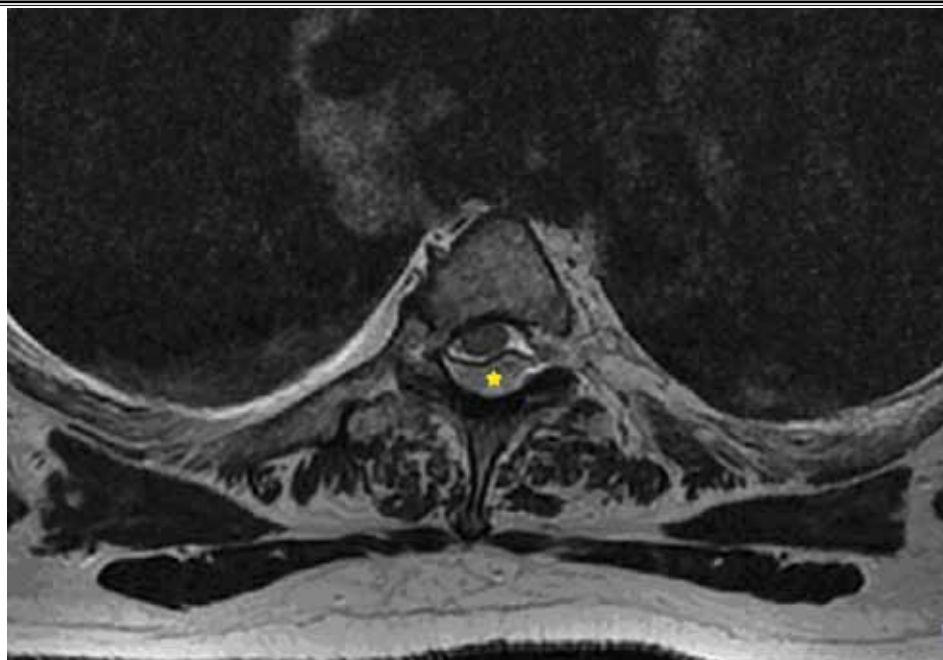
Axial T2 weighted MRI showing large epidural hematoma (marked by a star).
